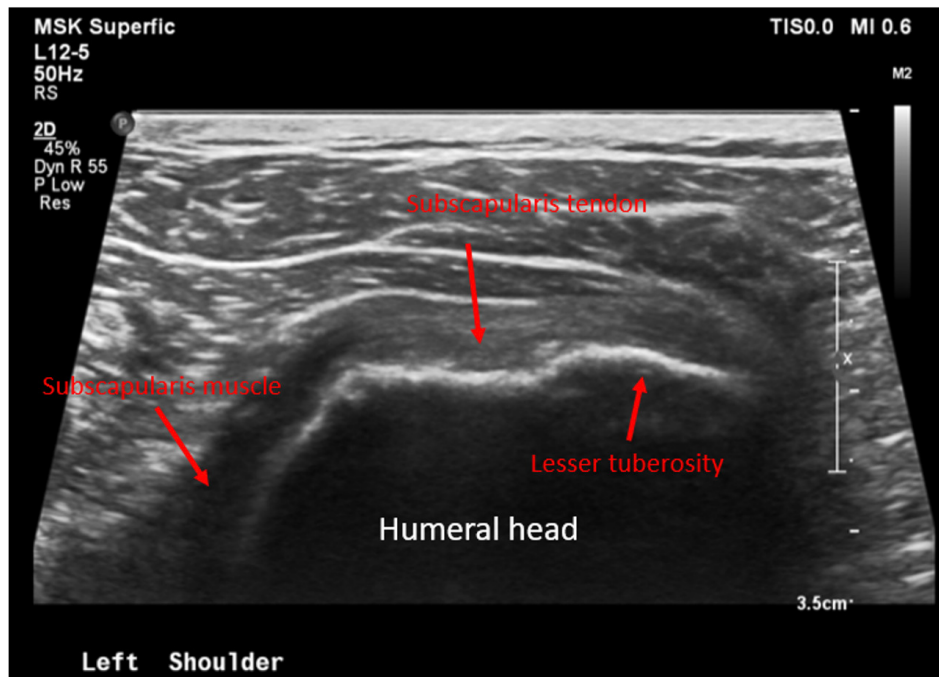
Patient #1 representative 6-month post-operative ultrasound showing intact subscapularis tendon with normal fibrillar echogenic tendon architecture and no evidence of tendinosis or tear.
